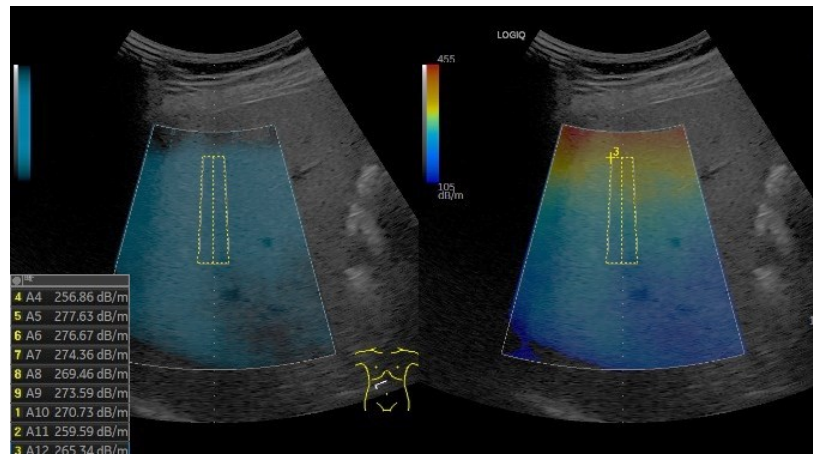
Quantitative Ultrasound for Liver Steatosis Assessment (UGAP)
